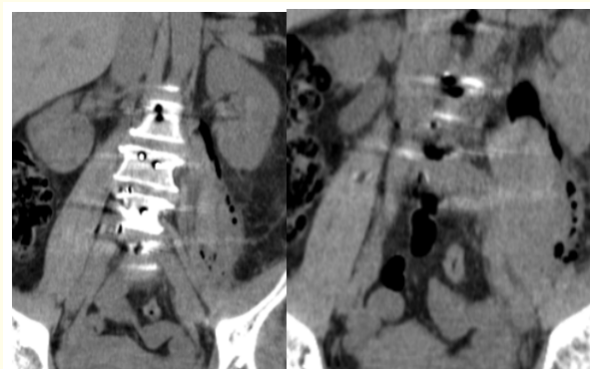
Postoperative CT scan shows left psoas enlargement with gas phenomenon.
